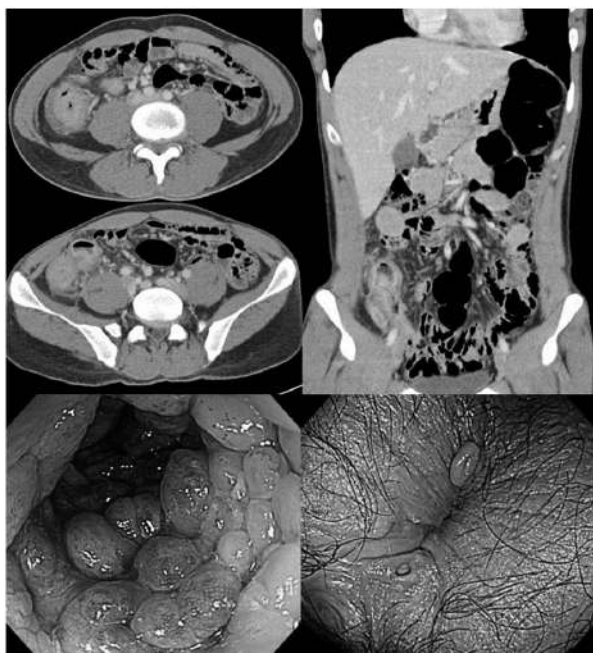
Computed tomography and colonoscopy.
